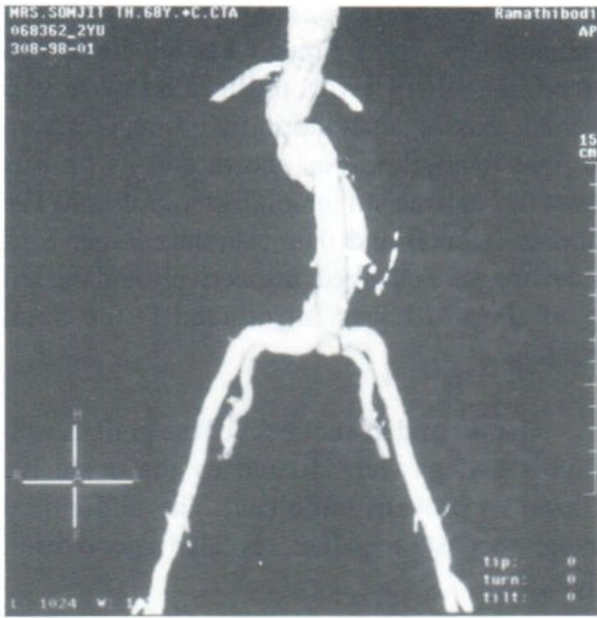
Follow up CTA, four days post the procedure.
